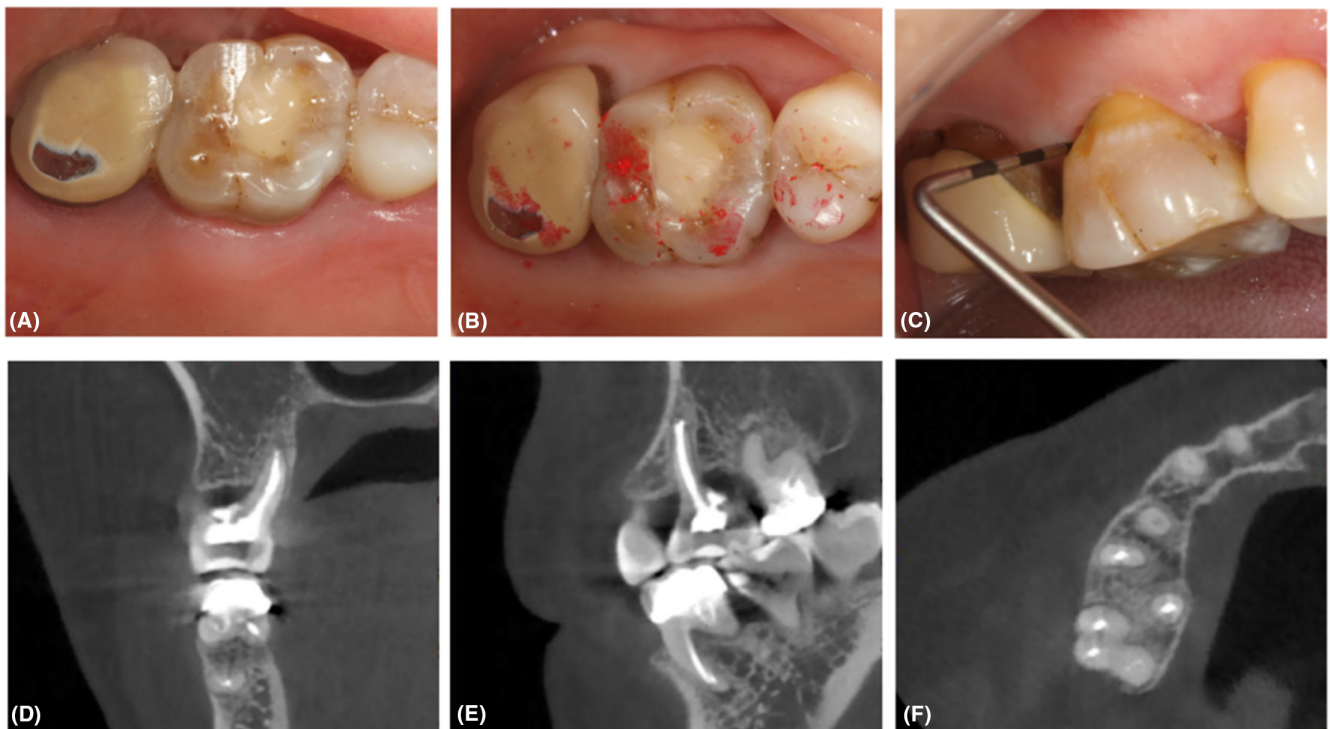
Intraoral and radiological examination of Tooth 16, 8 months after apical surgery in August 2022. (A) Occlusal surface. (B) Occlusal situation. (C) Horizontal probe. (D–F) CBCT. (D) Coronal scan. (E) Sagittal scan. (F) Axial scan.
